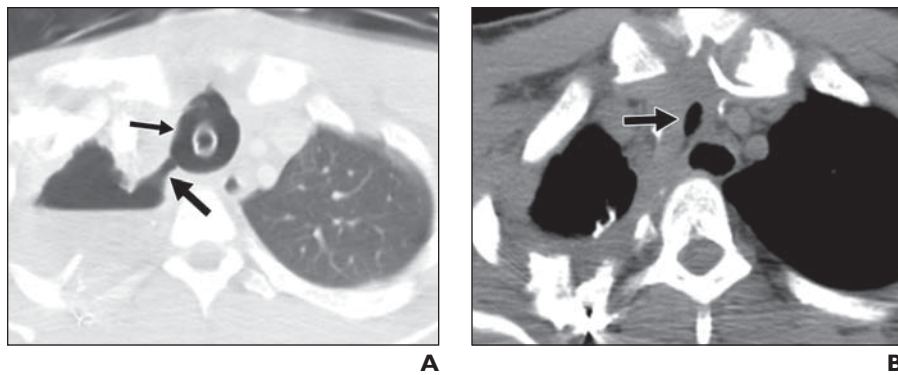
32-year-old man with tracheal stenosis. A, CT image shows overdistension of endotracheal tube cuff (*thin arrow*) and tracheopleural fistula (*thick arrow*). Note right hydropneumothorax. B, CT image obtained few months later shows development of tracheal stenosis (*arrow*).
